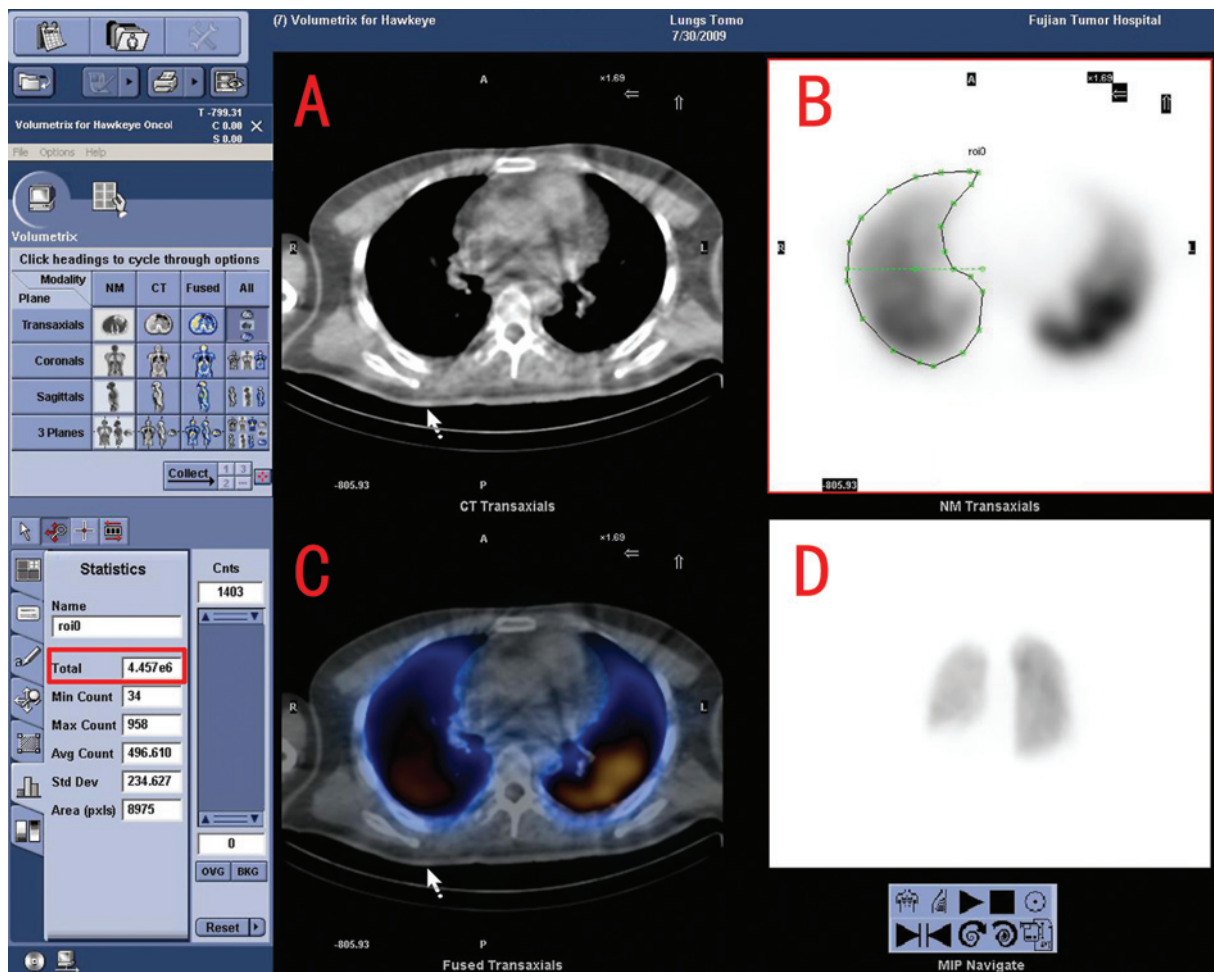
Image of lung perfusion SPECT scanning. (A) Computed tomography (CT) image; (B) SPECT image; (C) fusion image; (D) coronal section image. The count at the left marked in red is the radioactive count of the area outlined in B.
